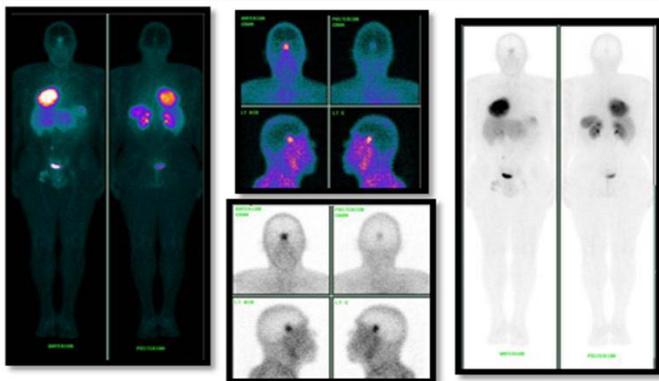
Somatostatin scintigraphy.
